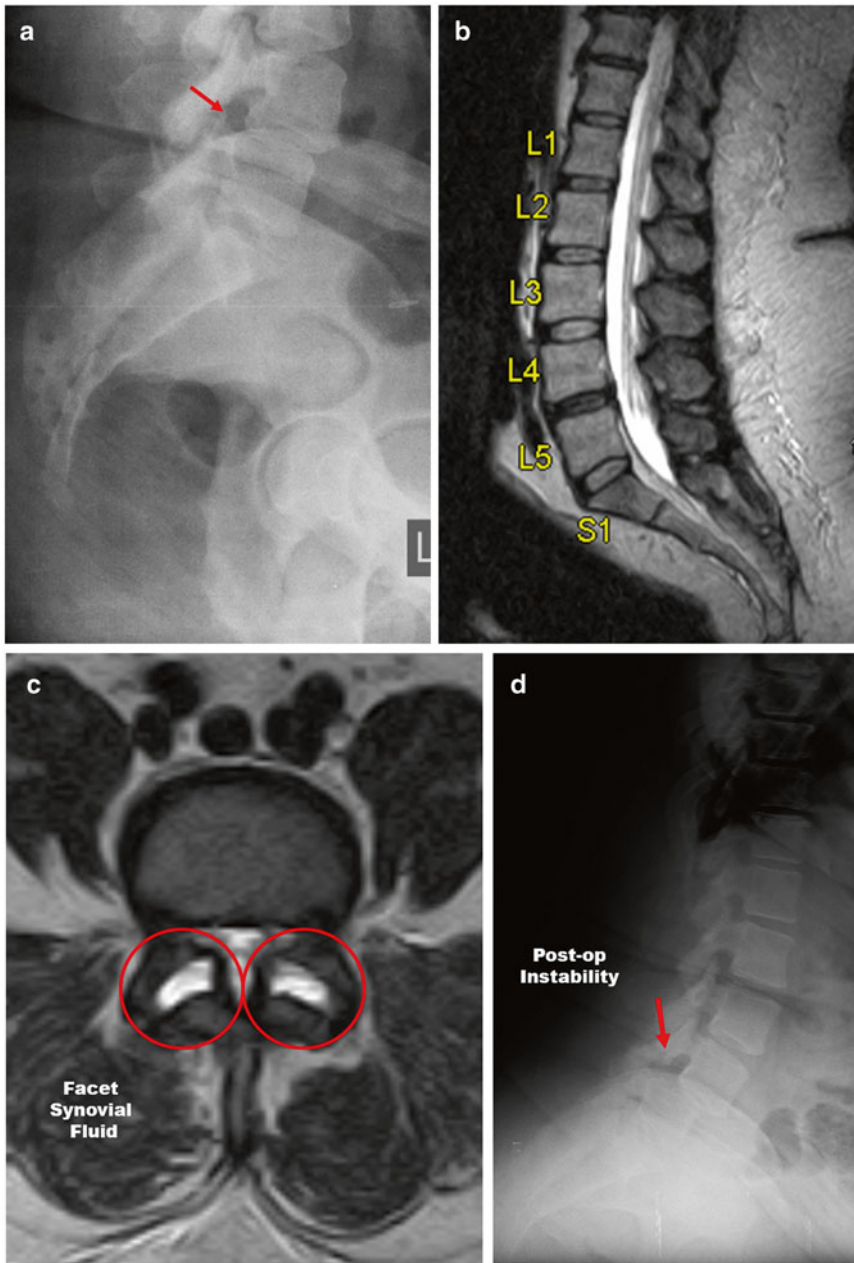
Fifty-two-year-old female presented with severe low back pain and bilateral L5 radicular symptoms following a “Minimally Invasive Decompression.” (a, b) Lateral plain radiograph taken prior to index surgery with a *grade I L4–5 degenerative spondylolisthesis* with 1–2 mm of anterolisthesis and a recumbent MRI that deceptively shows a degenerative disc at L4–5 and no
